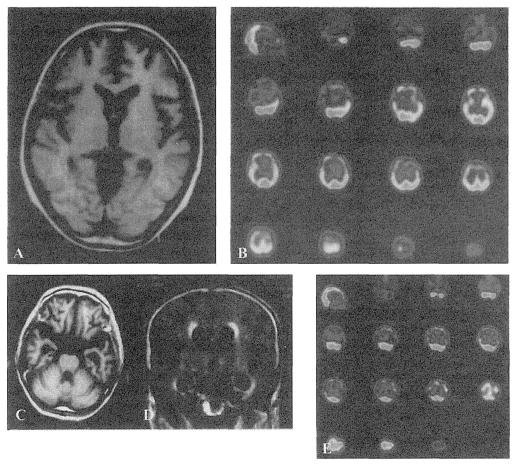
Neuroimaging of Kii ALS and PDC. Kii ALS cases show no or mild atrophy of the frontal and temporal lobes on magnetic resonance imaging (a) with obvious decrease in cerebral blood flow of the frontal and temporal lobes on SPECT with a tracer technetium (^{99m}Tc) ethyl cysteinate dimer (b), while Kii PDC cases show marked atrophy of the frontal and temporal lobes with ventricular dilatation on magnetic resonance imaging (c) with marked loss in cerebral blood flow of the frontal and temporal lobes on SPECT (d). Note that the atrophy and decrease in cerebral blood flow are symmetrical.
